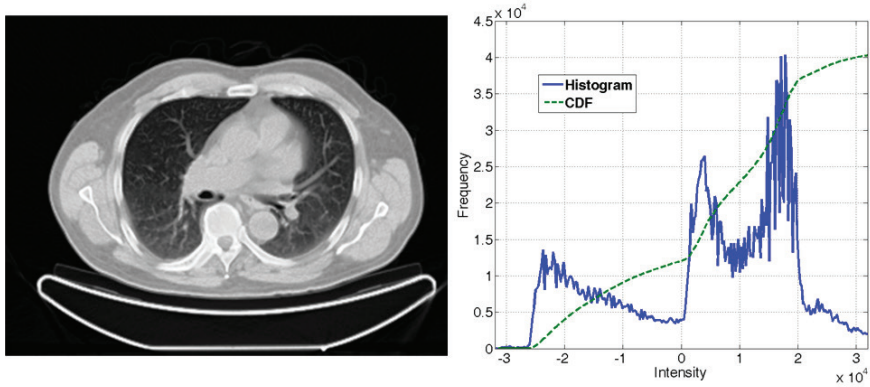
CT slice from Fig. 14.9 after histogram equalization with a corresponding intensity histogram, using only the pixels within the region surrounding the trunk. The number of bins is 256. The cumulative density function is now approximately linear. The intensity values are no longer related to Hounsfield units. Owing to the better distribution of the intensity values, all of the structures of interest, including the bone and the bronchi of the lung, are visualized simultaneously.
